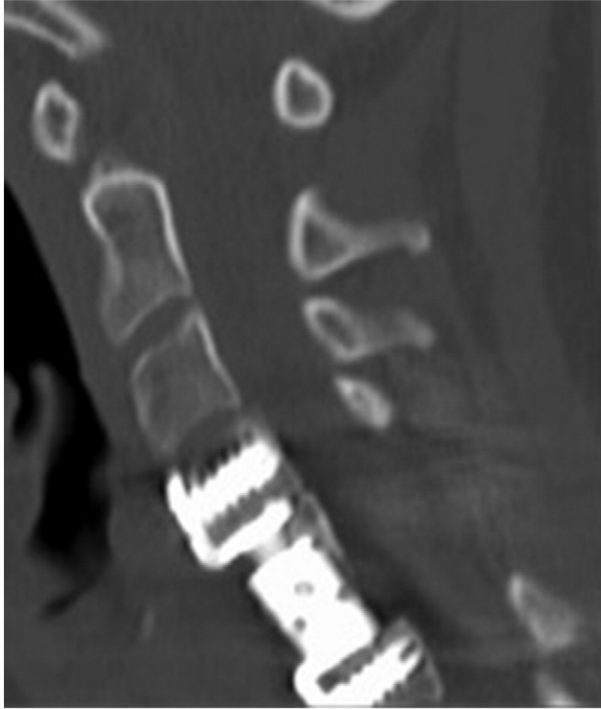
The postoperative CT at one year demonstrates a satisfactory placement of expandable cage at C5 without evidence of migration. The remnant of the posterior wall of the C5 vertebral body can be appreciated.
